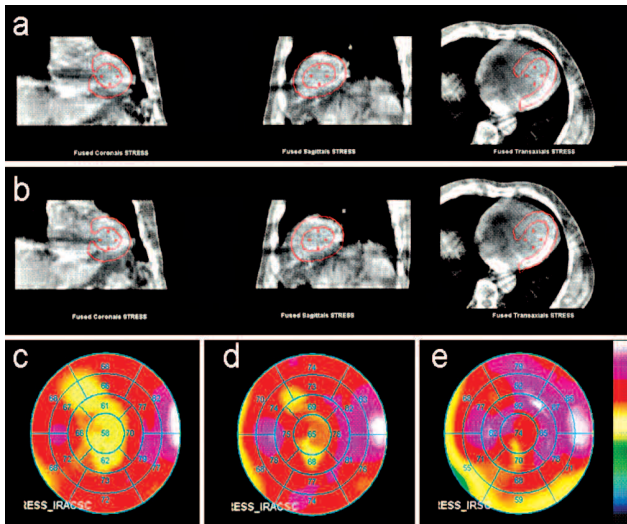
The rest study of a male patient: a) misregistered and b) corrected SPET/CT slopes. The maximum CT shifts needed for registration restoration was 4.9 pixels to the lateral direction and the sum of shifts in all directions was 5.1 pixels. The polar map of misregistered study is shown in (c), of the realigned study in (d) and of the non-attenuation compensated study in (e). The effect of registration correction on the diagnostic information of the study was minimal.
